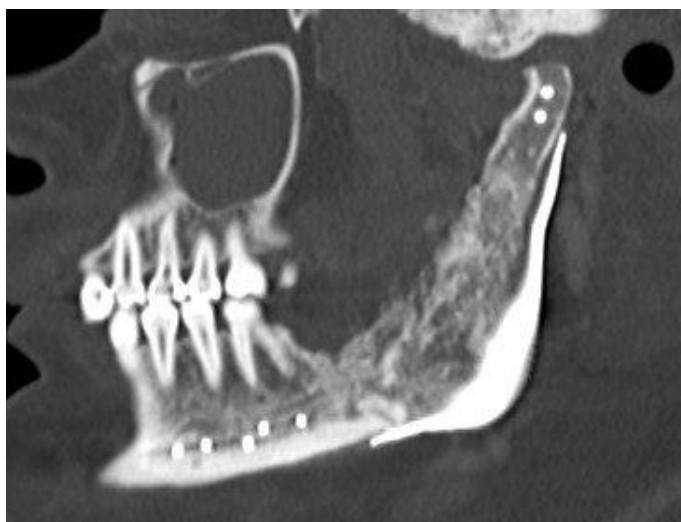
Sagittal view of the CT scan of the mandible 10 months after the operation. The formation of new bone tissue can be seen inside the PSI-plate.
